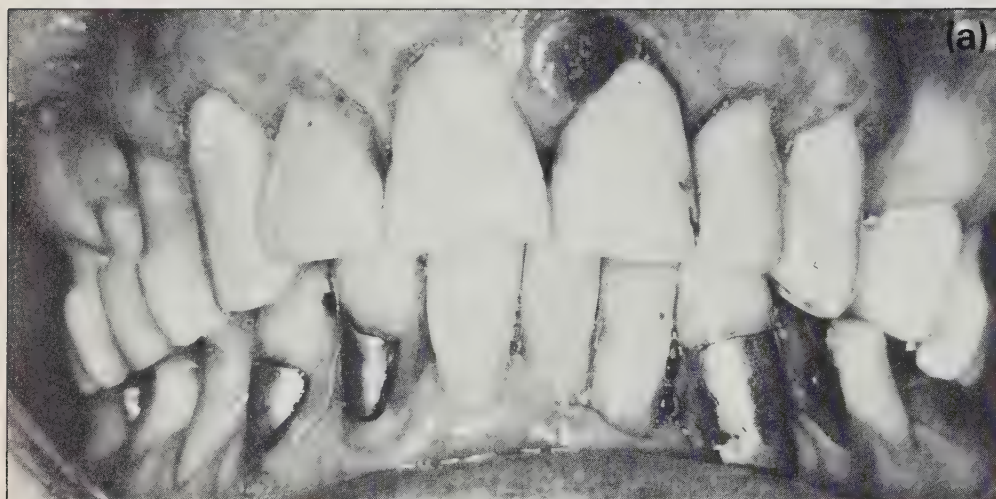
The chronic periodontal abscess: 1(a) pretreatment appearance, 1(b) radiographic appearance, and 1(c) one month after curettage therapy.
